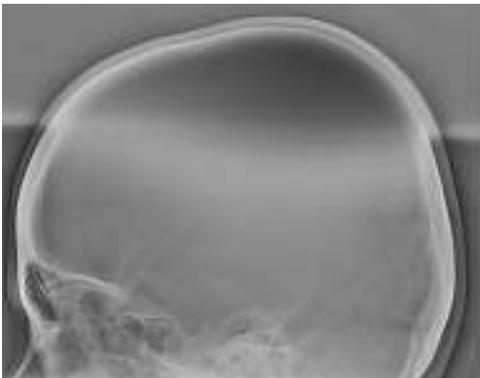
Lateral skull radiograph showing no evidence of any intracranial calcification
